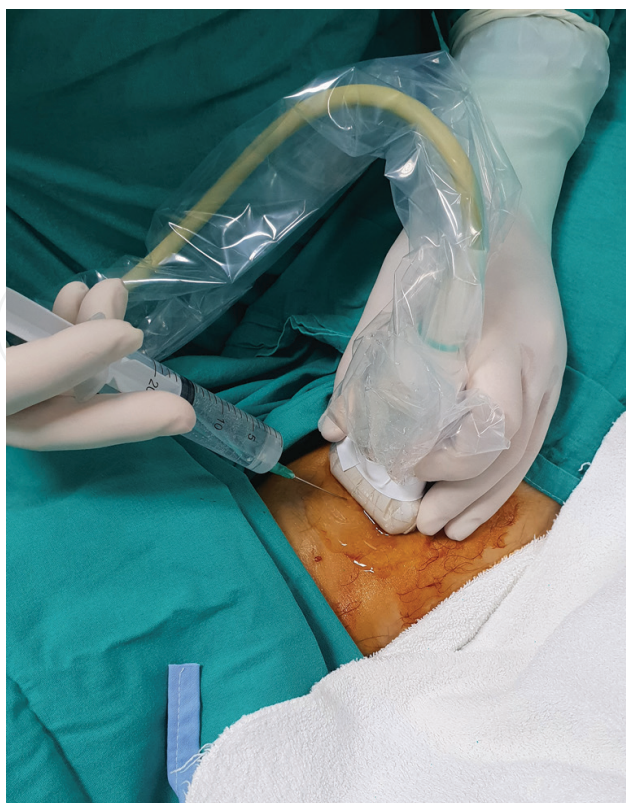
Popliteal artery access using ultrasonography probe after application of minimal local anesthesia.
